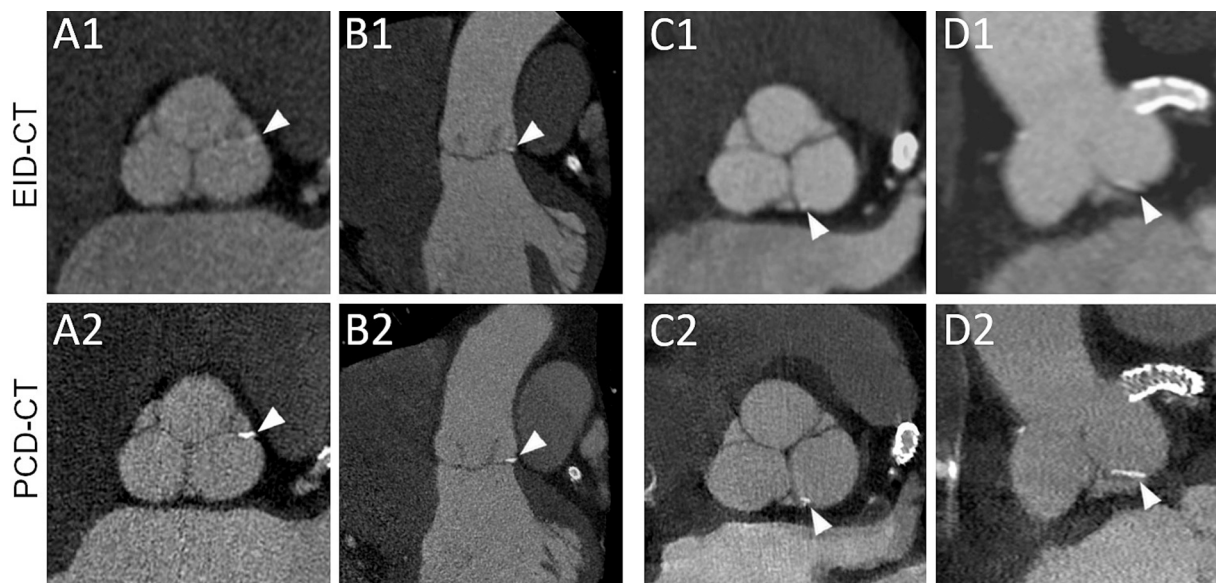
Corresponding images of aortic valvular calcifications of two patients obtained with EID-CT and PCD-CT. Two multiplanar reconstructions of a first aortic valve showing a small linear calcification on the commissure between the left and right cusps (arrowheads A1, A2, B1, B2). Two multiplanar reconstructions of a second aortic valve showing a linear calcification on the commissure between the left and non-coronary cusps (arrowheads C1, C2, D1, D2), almost invisible on EID-CT and easy to detect on PCD-CT. Both patients had stents in the left coronary artery.
